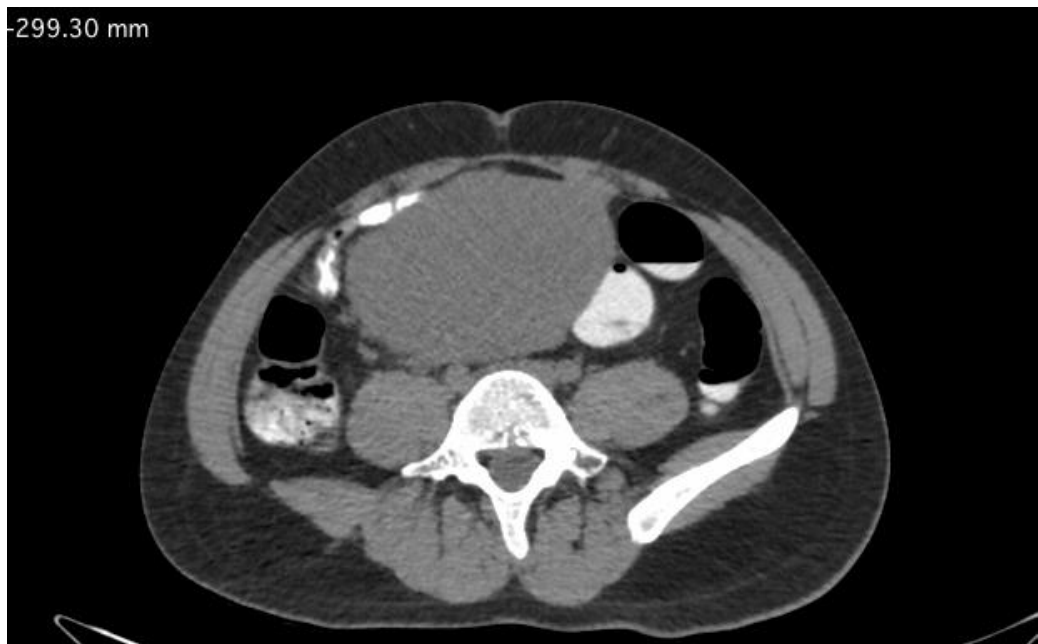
Abdominal CT scan
